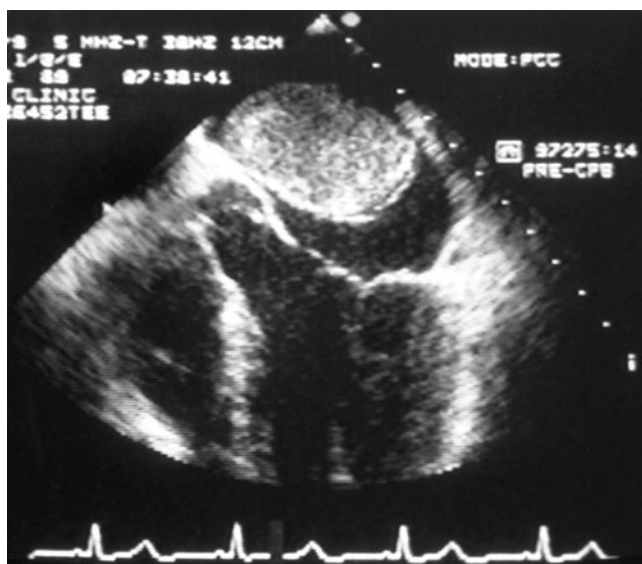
Transesophageal echocardiogram of large left atrial myxoma in patient presenting with symptoms of mitral valve disease. The tumor is attached to the interatrial septum above the normal mitral valve. (Reproduced with permission from Hall RA, Anderson RP: *Cardiac neoplasms*, in Edmunds LH Jr (ed): *Cardiac Surgery in the Adult*. New York, McGraw-Hill, 1997; p. 1350.)
